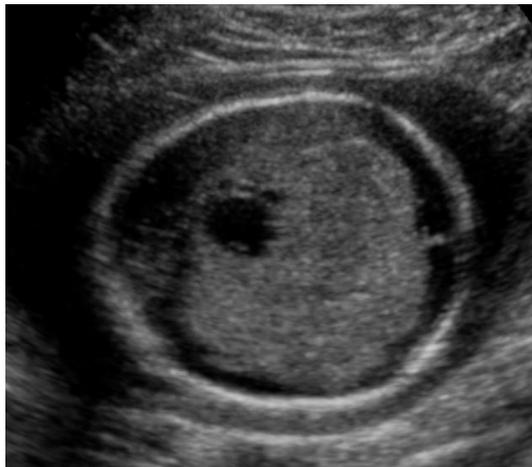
Axial ultrasound image of a fetal cerebral craniopharyngioma at 22 weeks. Note the large echogenic intracranial mass.
